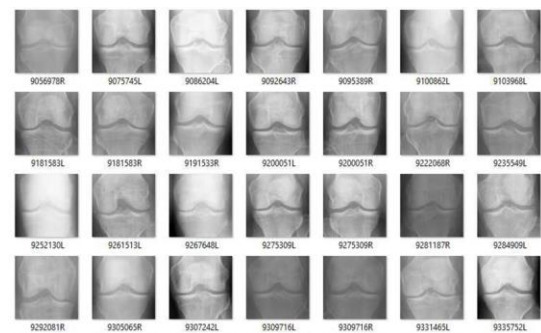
x-rays of doubtful
